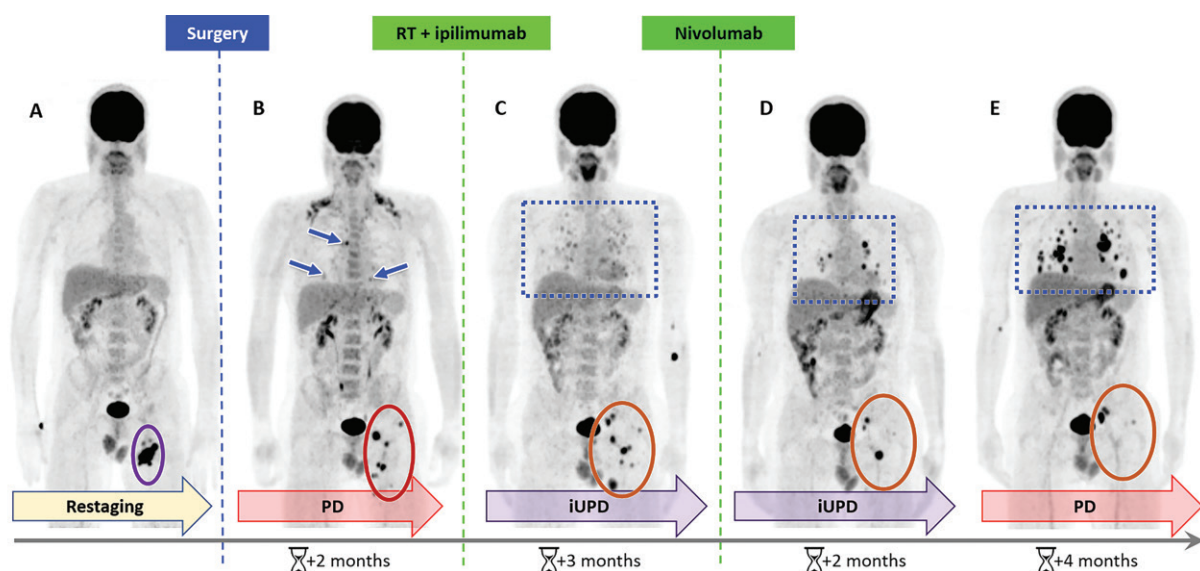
Immune-unconfirmed progressive disease (iUPD) followed by progressive disease (PD) after immunotherapy in a 45-year-old man with a history of left hallux melanoma treated with resection, homolateral inguinal lymphadenectomy, and adjuvant interferon. He underwent FDG PET/CT for restaging. *A*, FDG PET image shows secondary lesions in the left thigh (purple oval), which were subsequently resected. *B*, Follow-up image shows new lesions in the left thigh (red oval) and onset of metastatic pulmonary nodules (arrows). Ipilimumab and left thigh radiation therapy (RT) were initiated. *C*, Image for response assessment shows increased tumor burden in the pulmonary (dotted blue rectangle) and thigh (orange oval) lesions, in keeping with iUPD. *D*, *E*, After the immunotherapeutic agent was changed to nivolumab, images from subsequent studies show that the iUPD changed to PD in the same sites.
